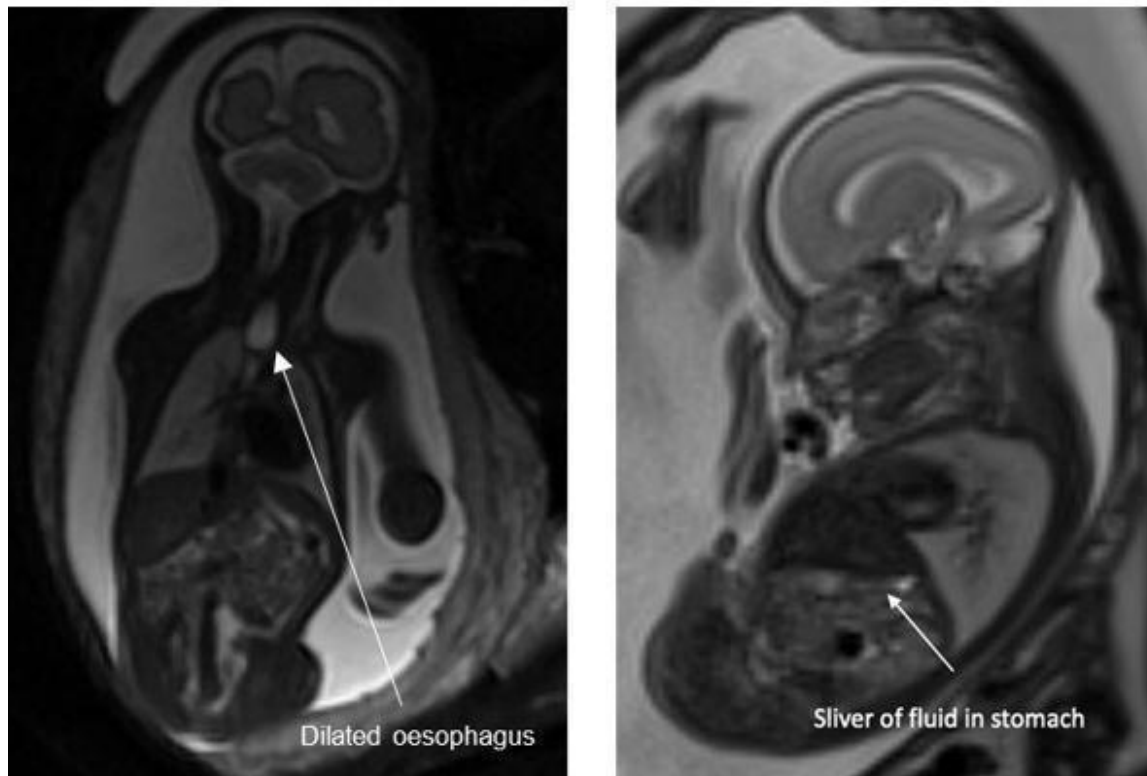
Coronal T2 SSFSE MRI image of dilated oesophagus (pouch sign) and small stomach in 30 week fetus with TOF/OA
